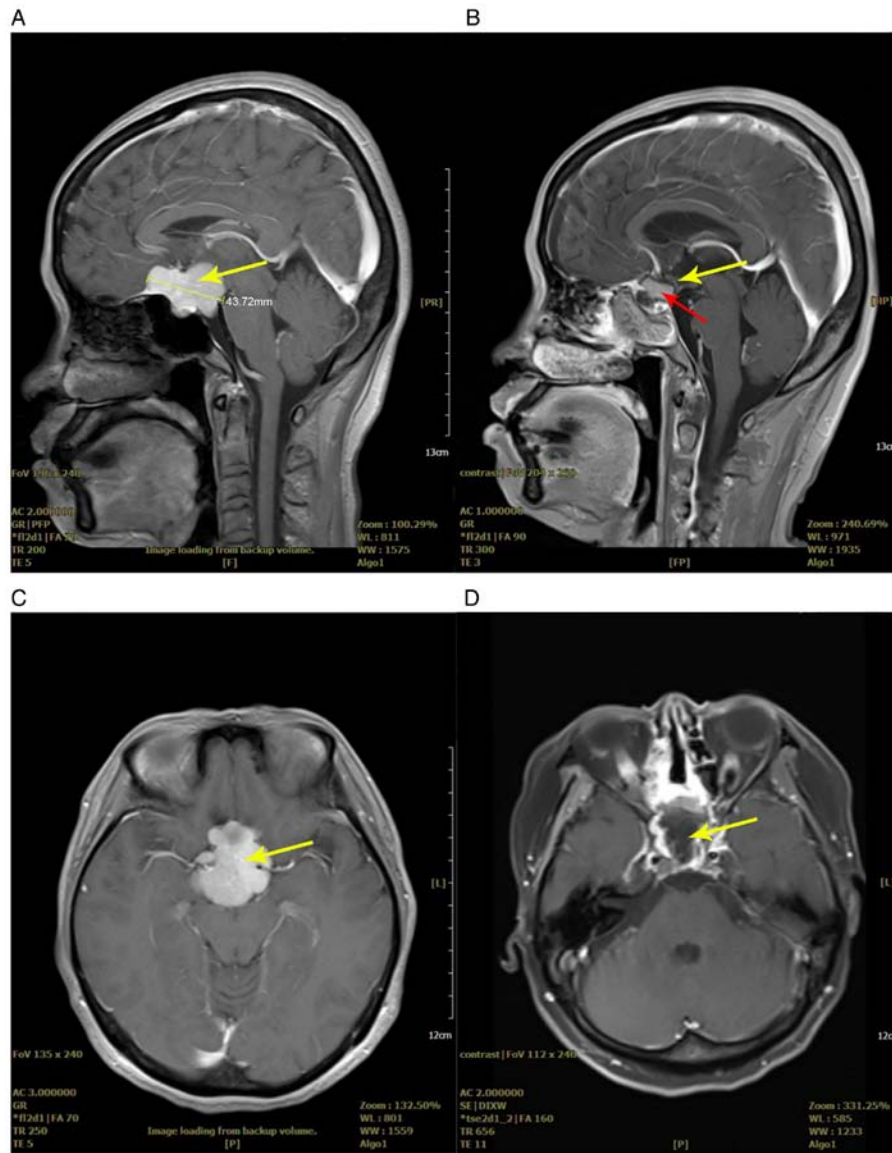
Case 2 of endoscopic transsphenoidal approach. Patient 2 was a 45-year-old female with decreased vision and headache. (A) Sagittal image of the preoperative MRI, showing an intrasellar tumorous lesion with a maximum diameter of 43.72 mm. (B) Sagittal image of the postoperative MRI, showing no remnant tumor tissue. (C) Axial image of the preoperative MRI. (D) Axial image of the postoperative MRI. The yellow arrow indicates the tumor or the tumor cavity. The red arrow indicates the fat-filled cavity after tumor removal.
